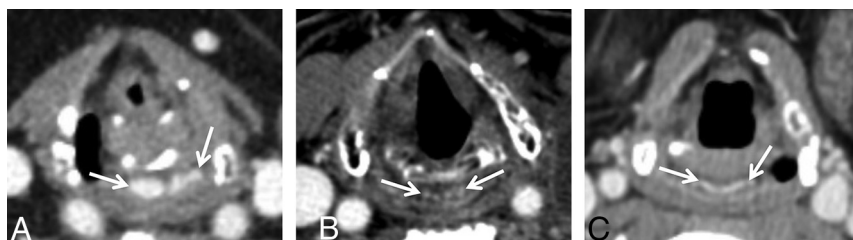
Axial contrast-enhanced neck CT images in 3 different patients demonstrate representative examples of bilobed (arrows, A), dot-dash (arrows, B), and linear (arrows, C) PCVP morphology.
